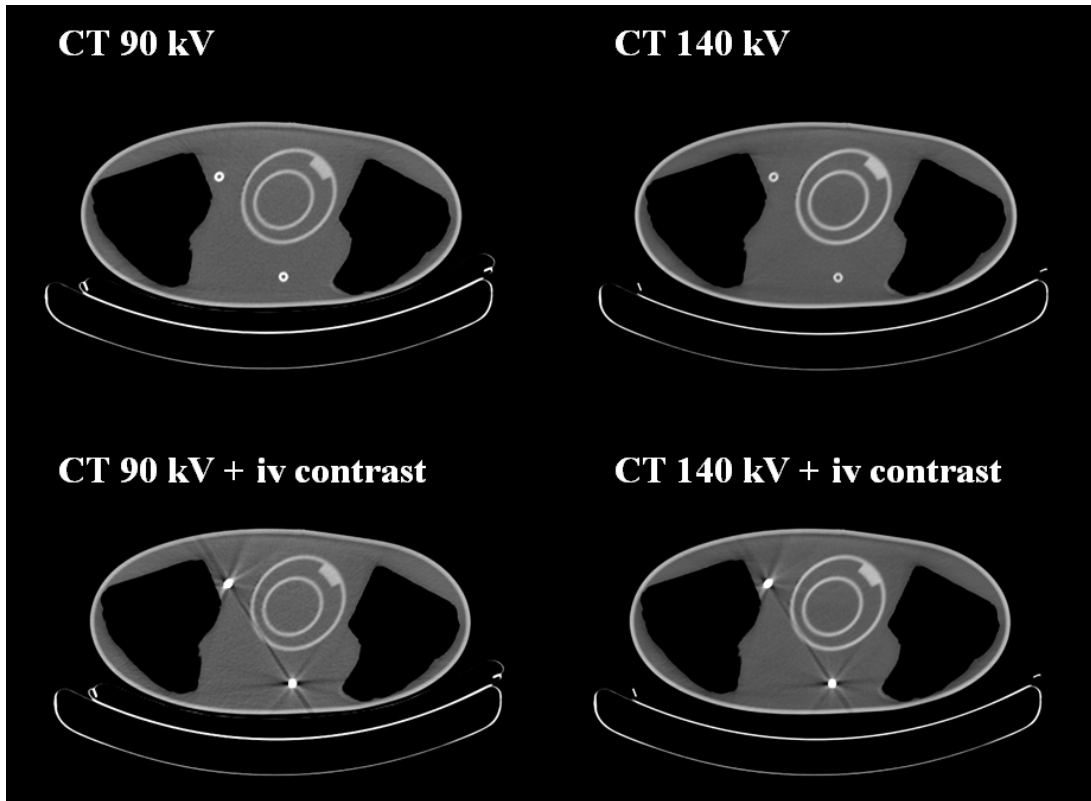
Reconstructed transaxial CT scans at two energies and with and without contrast present. The contrast induces streak artefacts at tube sites, slightly worse at 90 kV than at 140 kV.
